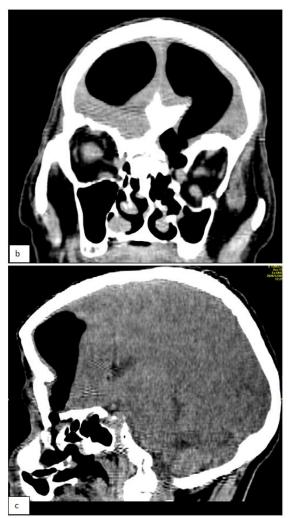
Cerebral CT in parenchymal window (a: axial section, b: coronal section, c: sagittal section) showing a communication between the left frontal sinus and the frontal horn of the homolateral lateral ventricle with pneumoventriculia
